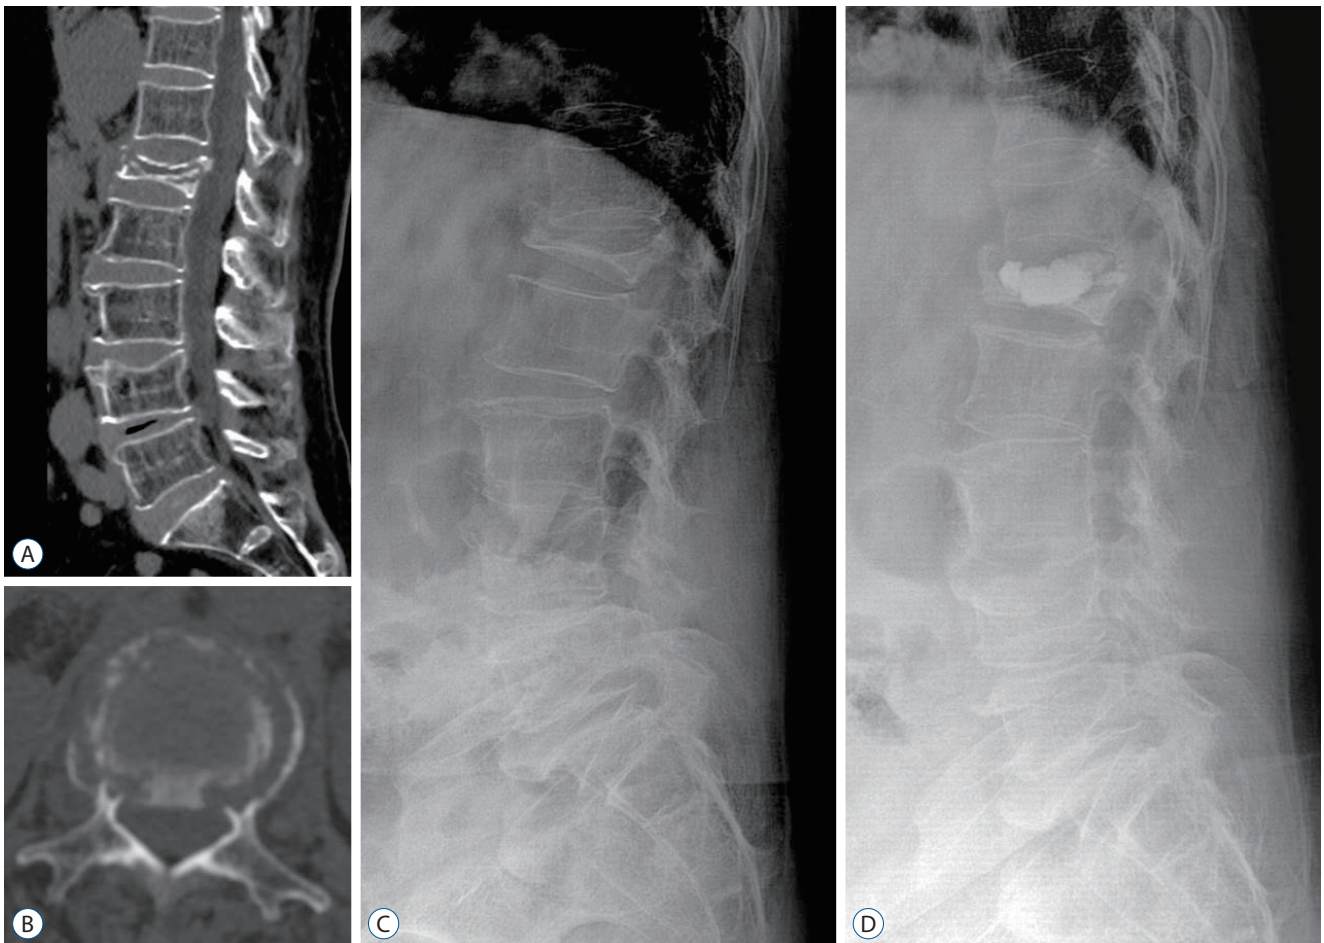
A 78-year-old female patient with a L1 burst fracture (thoracolumbar injury classification and severity score 4 and McCormack's load sharing score 7) was treated conservatively using teriparatide with vertebroplasty because of congestive heart failure and old age. Sagittal (A) and axial (B) view of computed tomography at baseline shows L1 burst fracture with $\geq 70\%$ of compression ratio and retropulsed bony fragment. Lateral plain X-ray at 12-month (D) shows similar kyphotic angle and restored segmental vertebral kyphotic angle with re-expanded vertebral body after cement filling compared to baseline (C).
